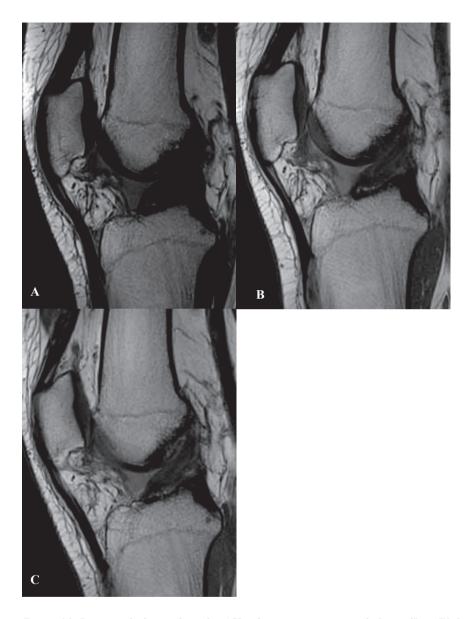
Persistent high signal in the ACL after primary repair with InternalBraceTM Ligament Augmentation, as seen on sagittal proton density weighted MR images. A, At 6 months, ACL repair is hyperintense due to post-operative edema. High signal intensity of the repair persists at 12 (B) and 24 (C) months post-operatively.
